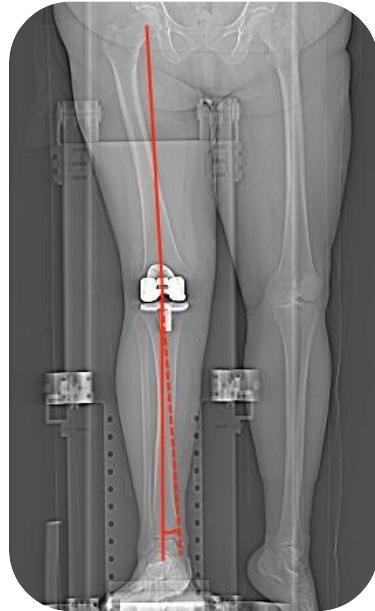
Hip-knee-ankle angle measured from the CT topogram with the leg mounted in a custom knee rig. The subject pressed against a pedal, resisting a 9-kg load.
